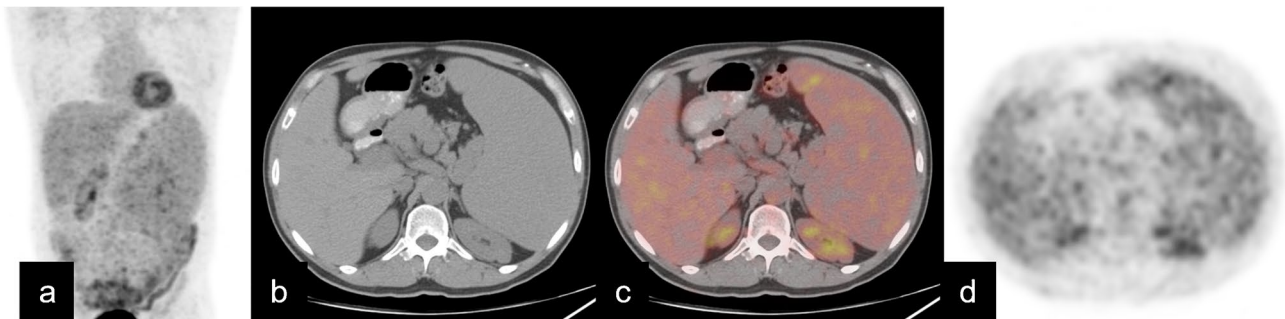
A representative case of non-FDG-avid MZL. A 52-year-old man with a biopsy-proven, early-stage, SMZL. Ki 67 index was 5%, and LDH level was 402. Predicted SUVmax = $-2.745 + 1.86$
